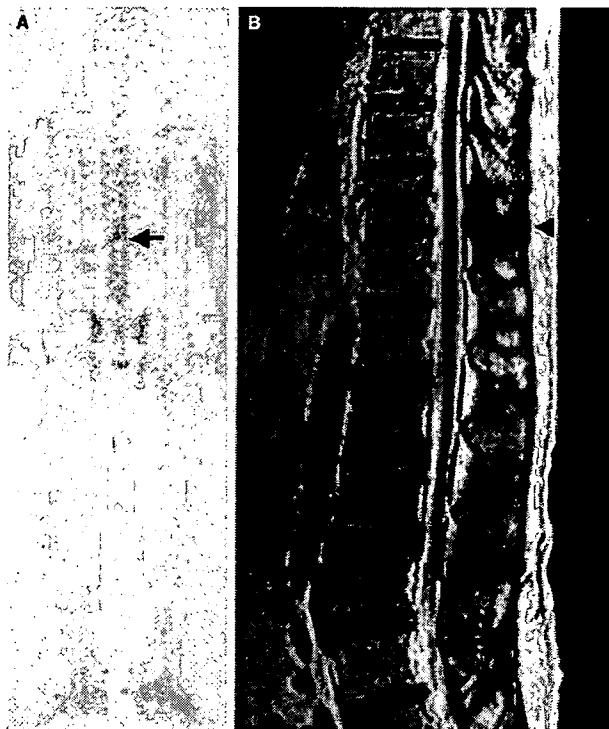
(A) Bone scintigraphy showing a hot spot in Th12 (arrow). (B) T2 weighted MR image revealing a sclerotic lesion in the acantha of this vertebrae (arrowhead)
